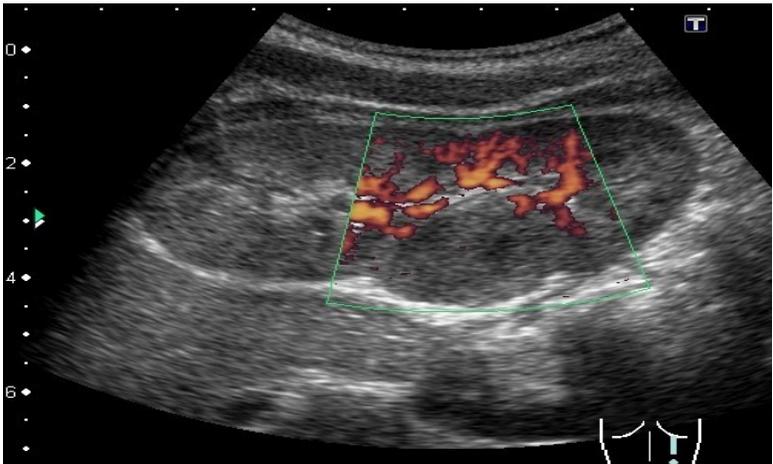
Color Doppler of renal
